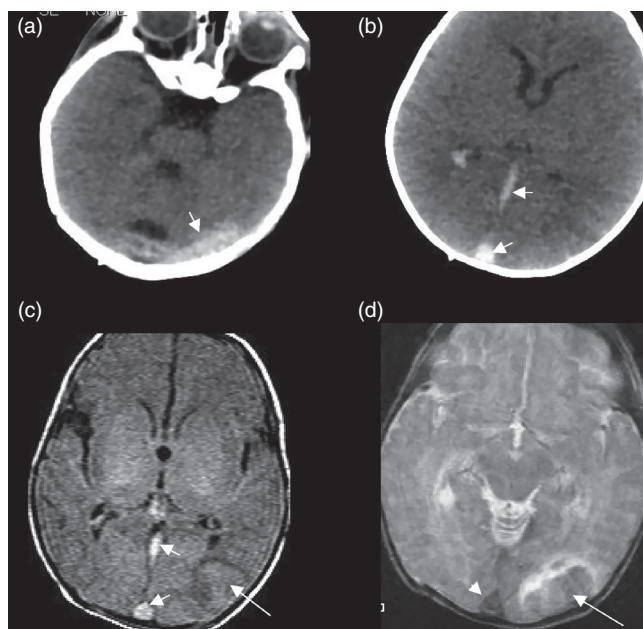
Venous thromboses (short arrows) with hemorrhages and infarctions (long arrows) on (a,b) axial CT, (c) axial T1, (d) axial GRE in infant with hypercoagulable state.
